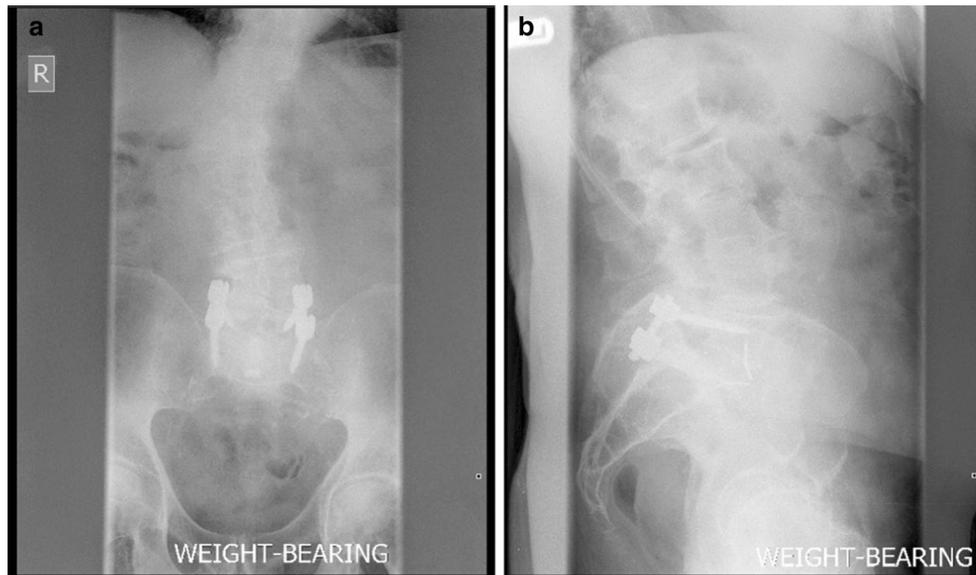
Postoperative standing a anteroposterior (AP) and b lateral plain radiographs of our patient
